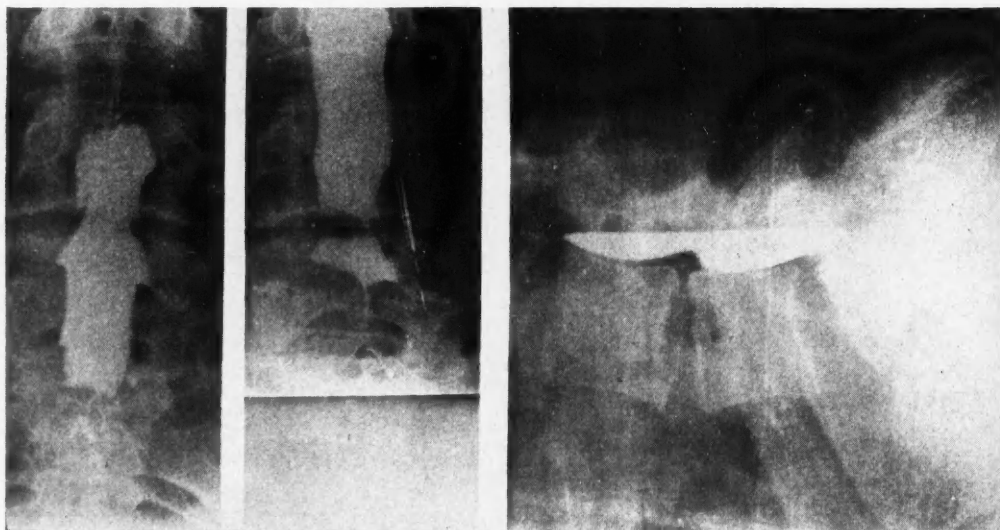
Variable appearance and incomplete delineation of a narrow "ridge defect" shown on fluorogram and lateral roentgenogram.
